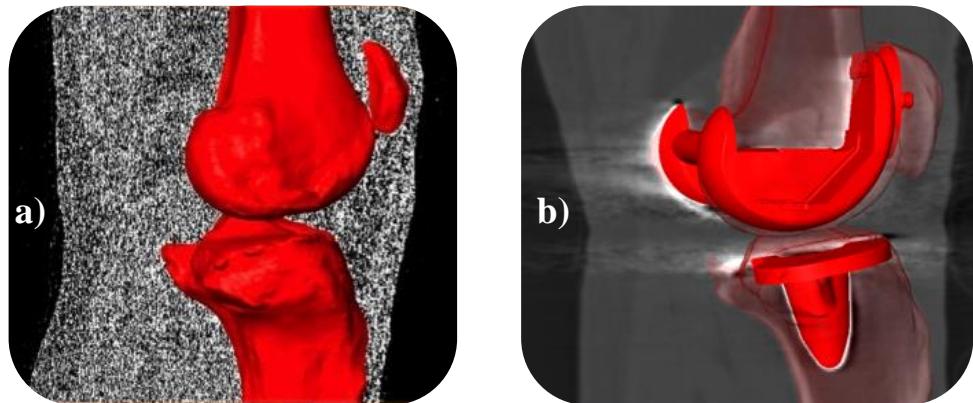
(a) 3D models of the femur, tibia and patella were segmented from preop CT images using statistical shape models followed by manual refinement; (b) 3D implant models, provided by the manufacturer, were fit automatically to the postop CT, allowing the relative bone-prosthesis positions to be determined.
